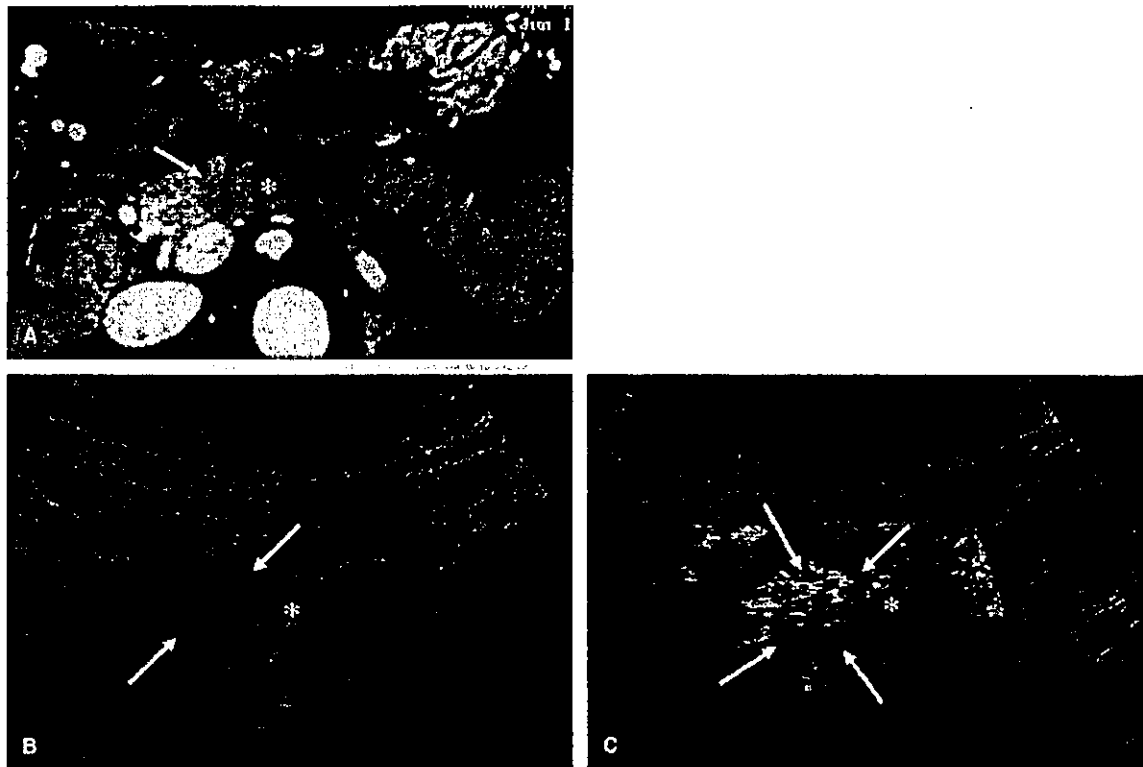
Case used for comparison with dynamic CT. This case had poorly differentiated ductal adenocarcinoma measuring 16 mm in the body. A: The arterial phase captured by dynamic CT. A low-density area (arrow) in the body and dilation (*) in the pancreatic duct in the tail are observed. B: The ultrasonographic image before injection of contrast medium. A hypoechoic tumor is observed in the body (arrow). C: The image captured by dynamic flow 35 seconds after administration of contrast medium. Vascular signals are observed in the tumor (arrow). The signal ratio was 13.9%. Asterisk, dilated main pancreatic duct in the tail.
